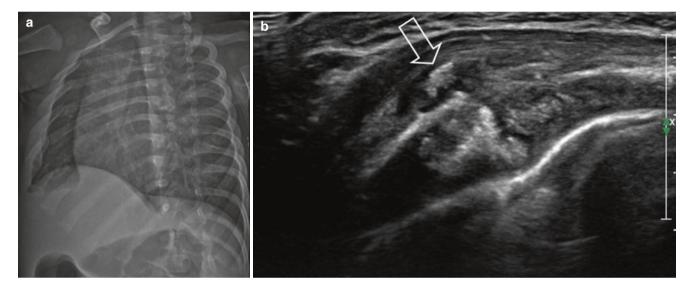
(a) Chest radiograph shows multiple recent anterolateral right sided rib fractures. (b) Ultrasonography shows beginning callus formation (arrow)
